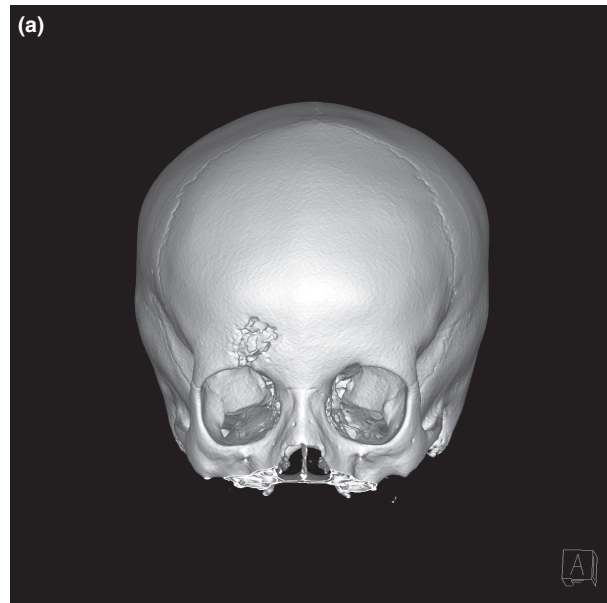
Computed tomography (CT) surface rendering of the bony erosion (A), compared with the more subtle soft tissue swelling overlying it (B).
